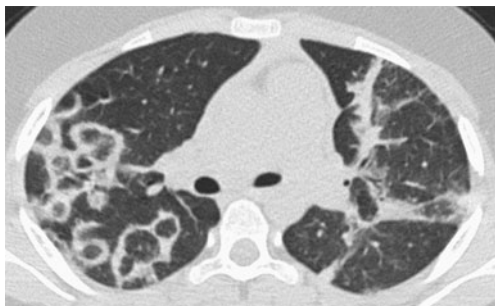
Reversed halo (atoll) pattern. A 24-year-old man developed a cough and breathlessness on exertion. HRCT image through the upper zones shows a classic reversed halo pattern. An underlying cause was not found, cryptogenic organizing pneumonia was diagnosed and the patient responded well to immunosuppressive treatment
